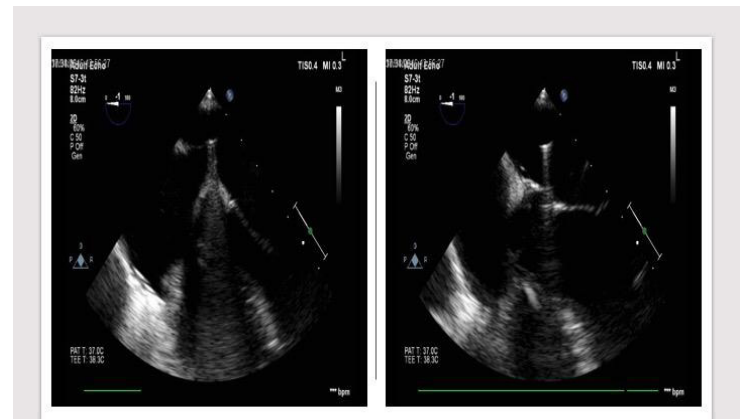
Transoesophageal echocardiography views demonstrating tenting of the inter-atrial septum (left) and subsequent advancement into the left atrium (right)
